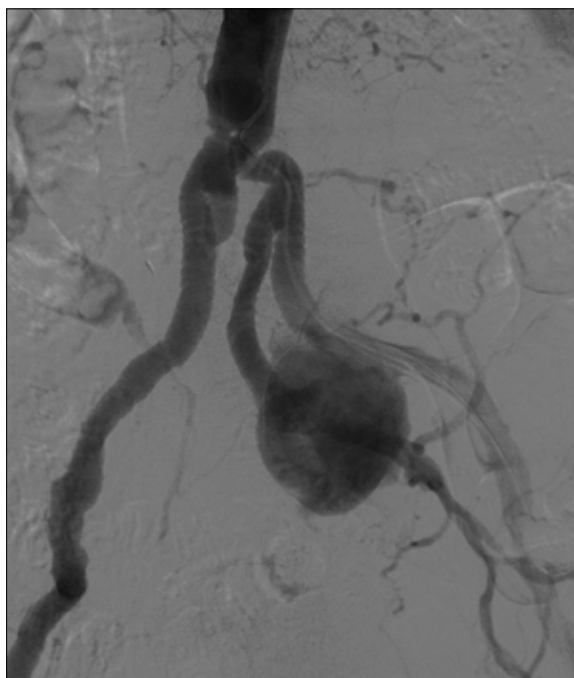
Pre-procedural Digital Subtraction Angiography (DSA), confirming CT-A findings and demonstrating a pseudoaneurysm on the left side with clear communication with both the iliac arteries. The complex anatomy of the upstream vessels on the left and a proximal occlusion of the right hypogastric artery are also shown.
